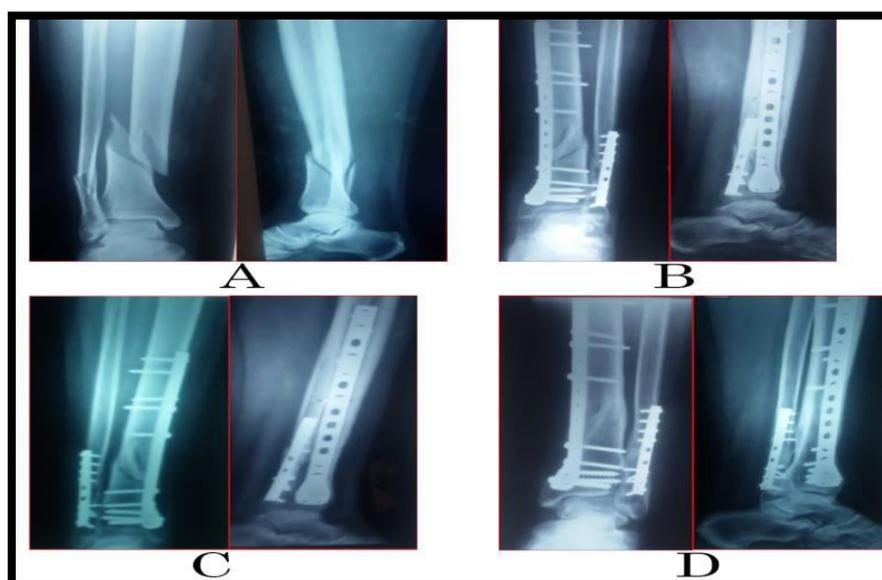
A case of male patient (22 years), no comorbidities, RTA, closed left fracture of lower third tibia 43A1 was fixed by MIPO, with fracture of fibula Webber C was fixed by 1/3 tubular plate. A: pre operative x-ray AP and lateral. B: post operative x-ray AP and lateral. C: follow up after 2 months AP and lateral. D:
